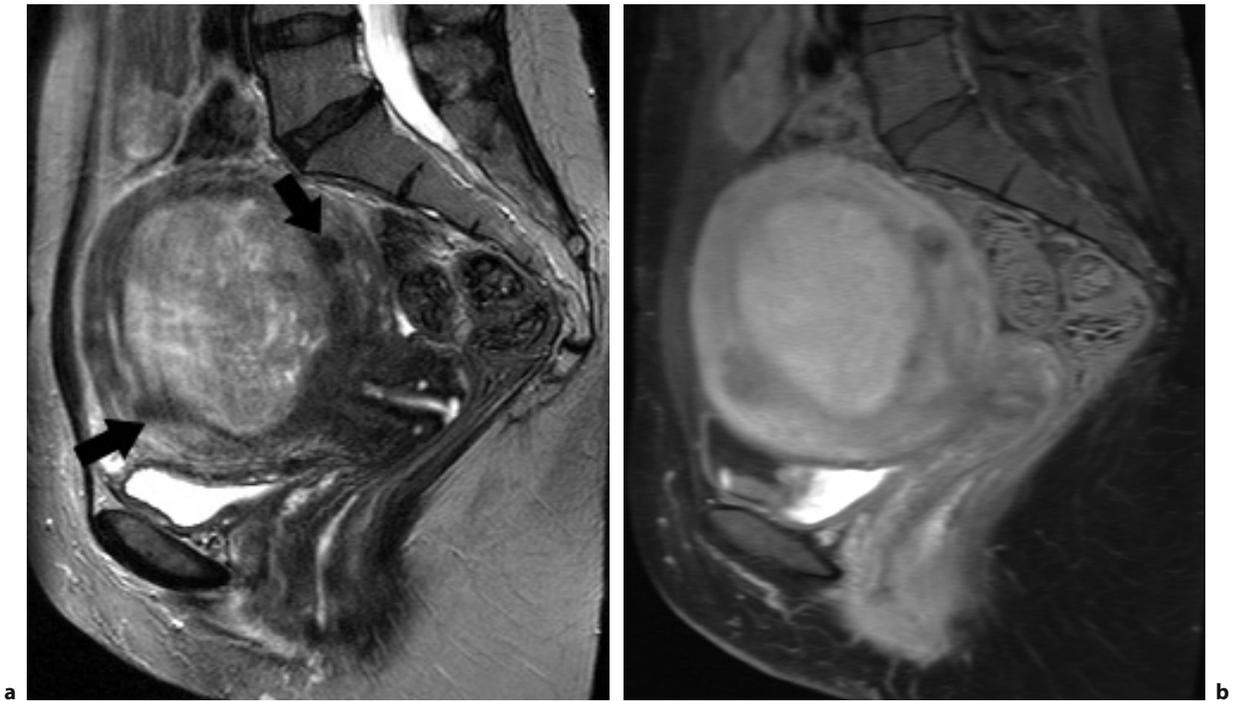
MRI of cellular leiomyoma. a T2-weighted sagittal image of the uterus demonstrating a large intramural cellular leiomyoma with homogenous high signal intensity compared to surrounding myometrium. Two small intramural leiomyoma show the typical low intensity signal (*arrows*). b T1-weighted contrast-enhanced fat-suppressed sagittal image showing marked enhancement of the intramural cellular leiomyoma which appears hyperintense compared to surrounding myometrium
